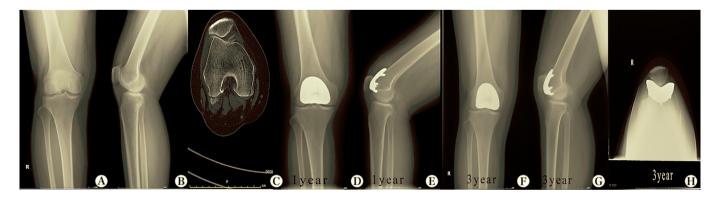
X-rays of the patellofemoral arthroplasty. (A) Preoperative anteroposterior X-ray of the patellofemoral arthroplasty. (B) Preoperative lateral X-ray of the patellofemoral arthroplasty. (C) Preoperative skyline view of the patellofemoral arthroplasty. (D) Postoperative anteroposterior X-ray of the patellofemoral arthroplasty taken at 1 year. (E) Postoperative lateral X-ray of the patellofemoral arthroplasty taken at 1 year. (E) Postoperative lateral X-ray of the patellofemoral arthroplasty taken at 1 year. (F) Postoperative anteroposterior X-ray of the patellofemoral arthroplasty taken at 3 years. (G) Postoperative lateral X-ray of the patellofemoral arthroplasty taken at 3 years. (H) Postoperative skyline view of the patellofemoral arthroplasty taken at 3 years. The X-rays showed a good position of the prosthesis with no loosening at 1 and 3 years postoperatively.
